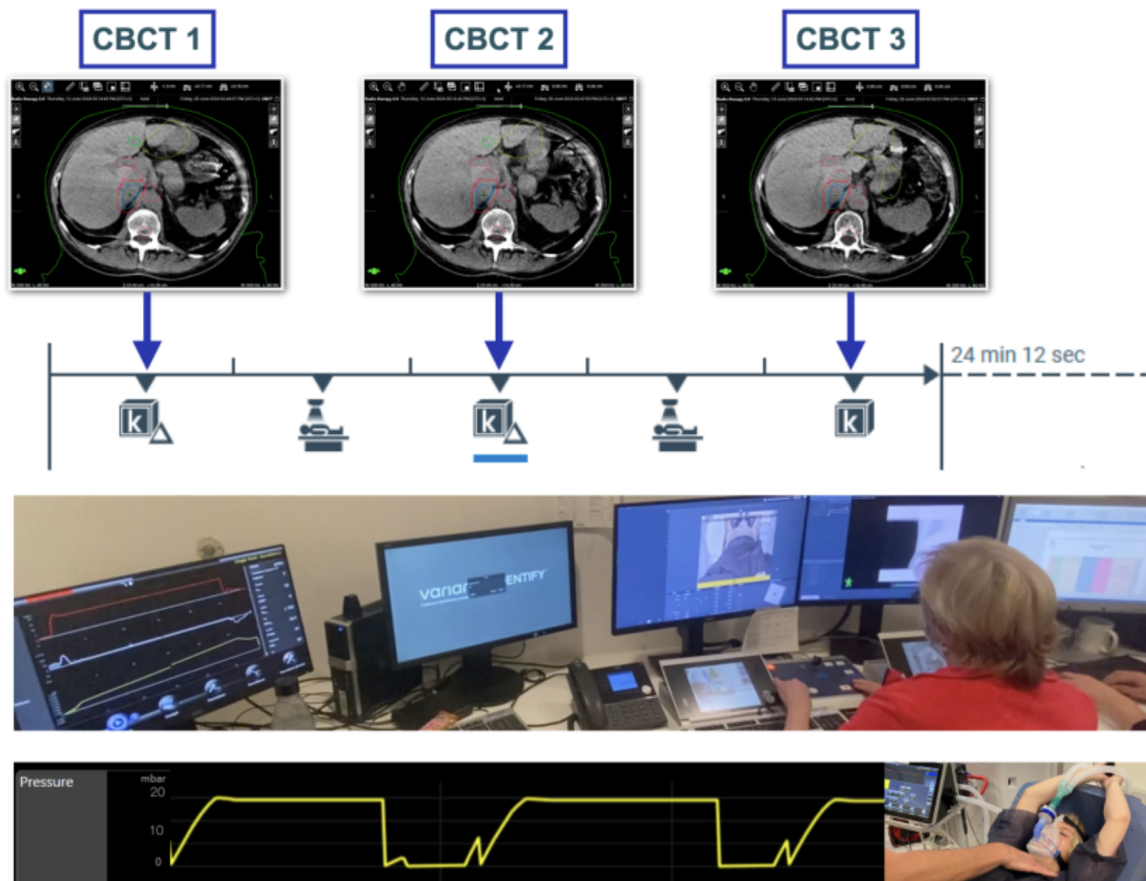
Cone-beam CTs (CBCTs) acquisitions for intra-fraction motion assessment.
